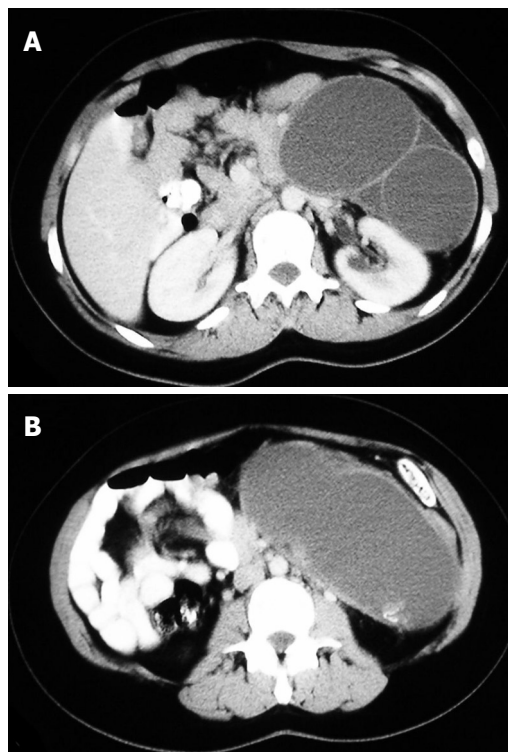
Axial CT scan showing a large bilocular cyst in the region of the body and tail of the pancreas (A) and a second more caudal axial CT slice (B).
